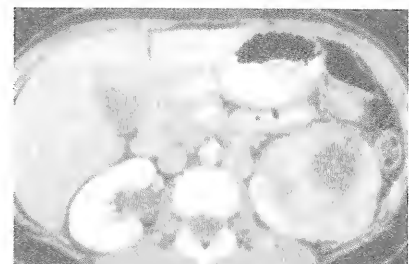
CT scan showing left renal cell carcinoma.
